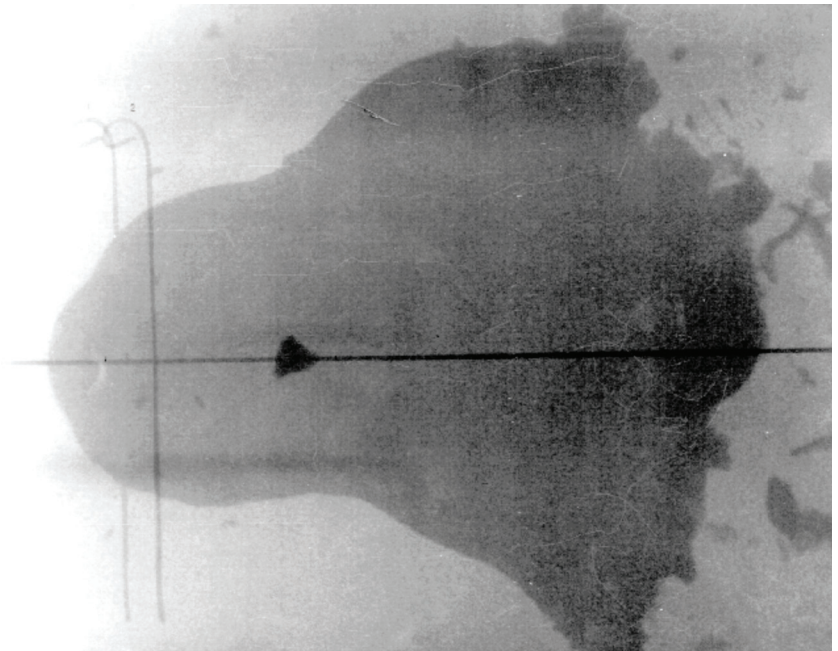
(Right) *X-ray of explosively formed projectile (EFP) detonation. Image courtesy of Applied Research Associates, Inc.*
